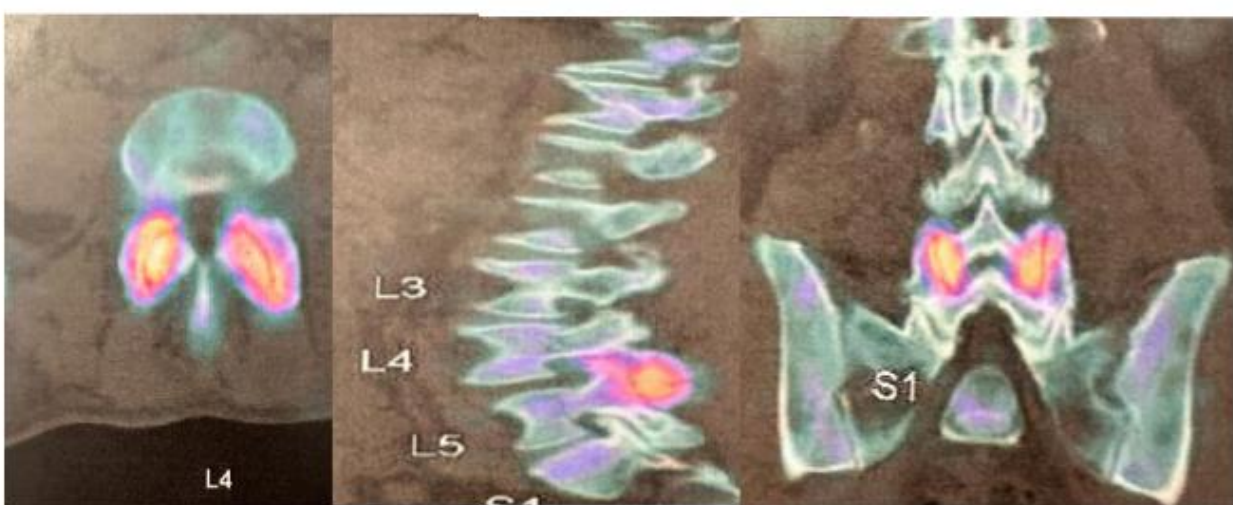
Fused axial, sagittal and coronal single photon emission CT with CT images demonstrate increased radiotracer uptake in within bilateral L4 to L5 facet joint with associated subchondral cysts and joint space narrowing compatible with degenerative facet arthropathy.
